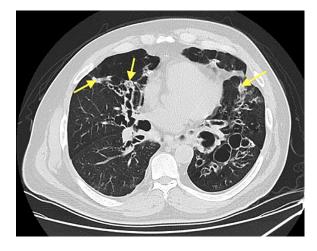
Chest computed tomography in parenchymal window showing bilateral cylindrical and cystic bronchiectasis with mucoid impaction (arrow).
